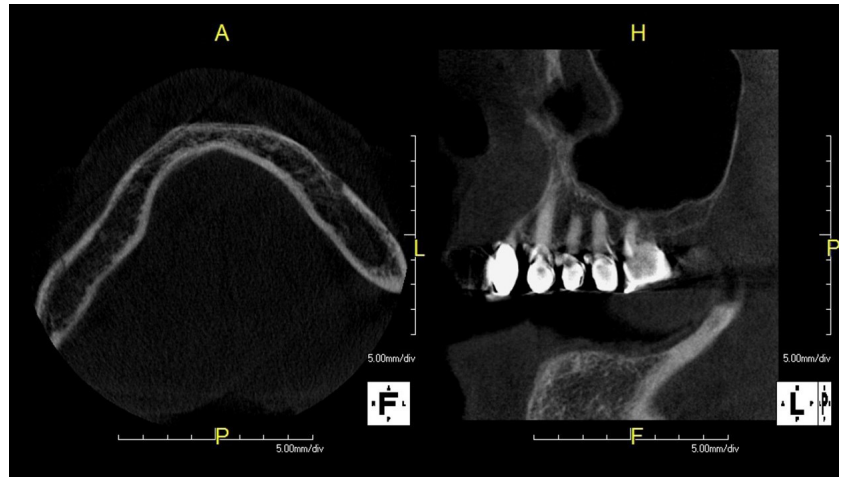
Cone beam CT scan
